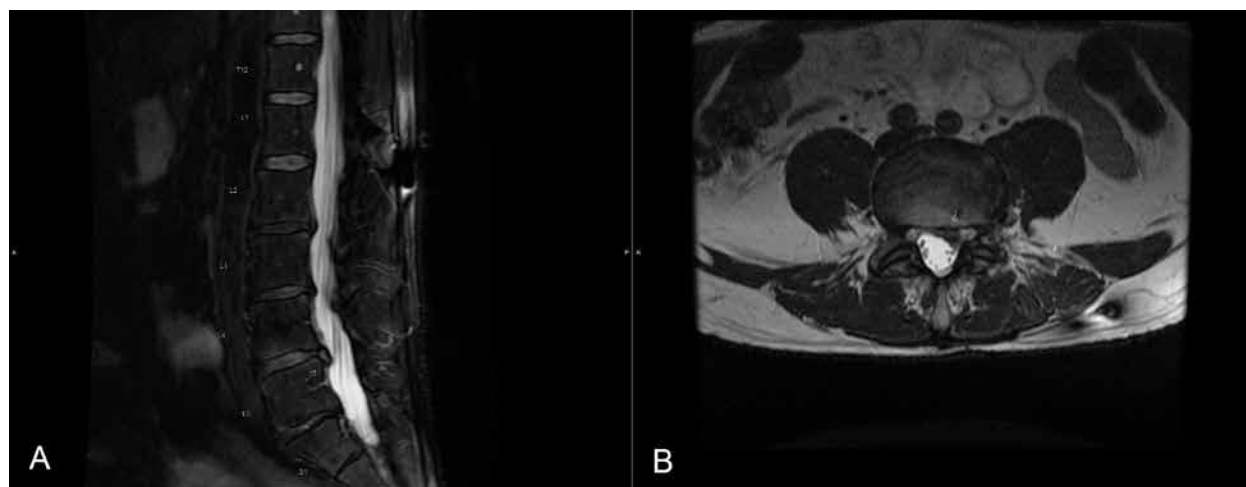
Magnetic resonance imaging of the patient's lumbar spine without contrast medium prior to lumbar discectomy demonstrates a left lateral recess disc extrusion at L4-L5 with displacement of the adjacent nerve roots. A: Sagittal, T2-weighted image. B: Axial, T2-weighted image.
